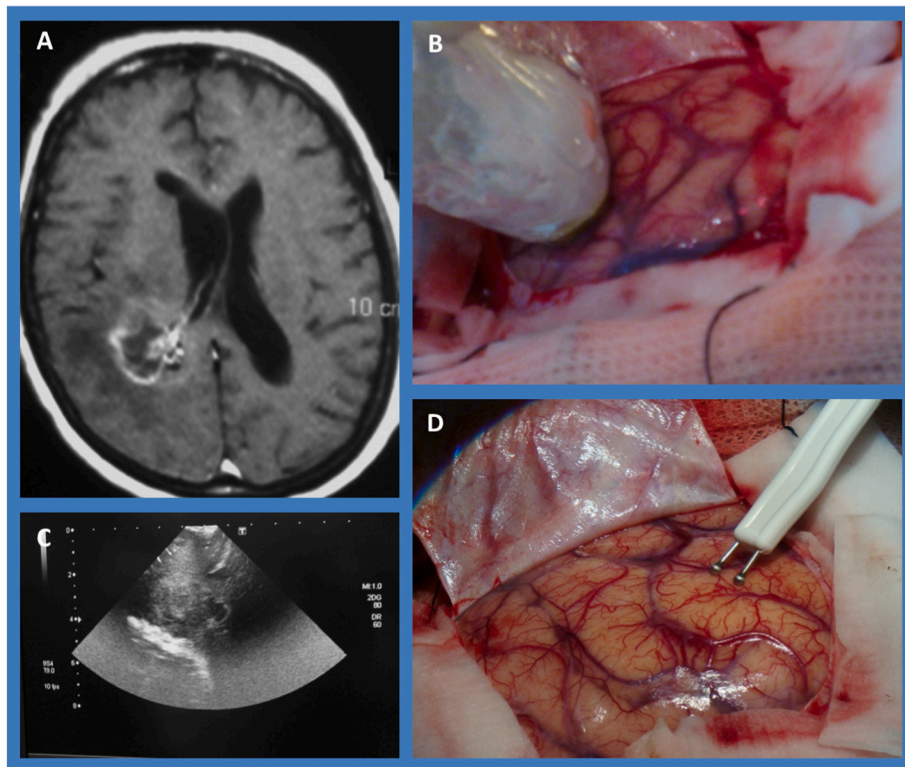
Case example of high grade glioma. A: Contrast MRI showing a lesion with both heterogeneous contrast-enhancing areas and cystic/necrotic appearance, involving the area of the motor tract projections in depth. B: In this case, ultrasound was used to localize the lesion. C: Ultrasound image showing an area of heterogeneous echogenicity that corresponds to the tumor. D: Cortical stimulation to locate the motor area.
